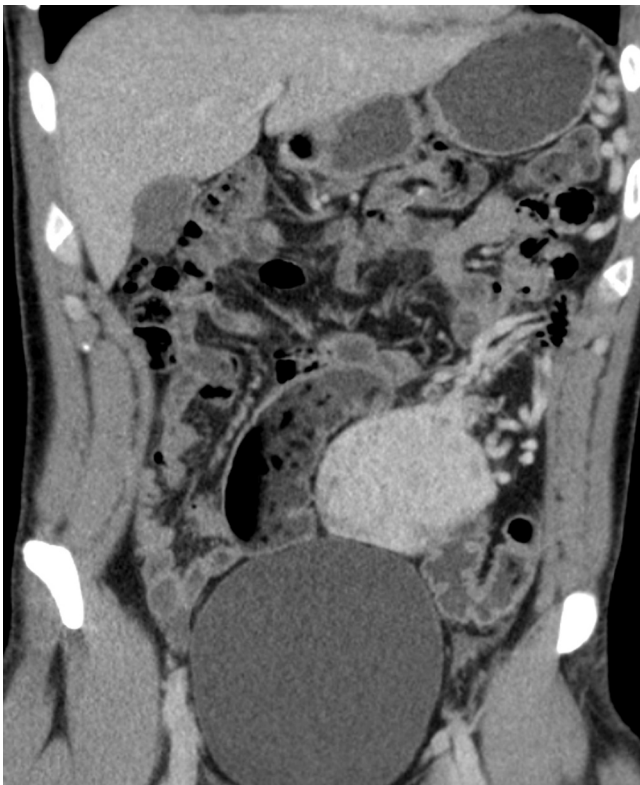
Abdominal CT-scan showing a hypervascularized solid centrally inhomogeneous tumor measuring 5.7 × 8.3 × 6.8 cm in the left lower quadrant with an emphasized vascular supply originating from the left gastroepiploic vessels.
